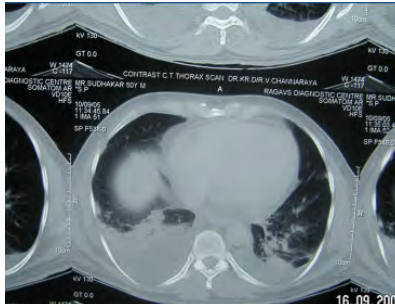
CT showing bilateral pleural effusion
